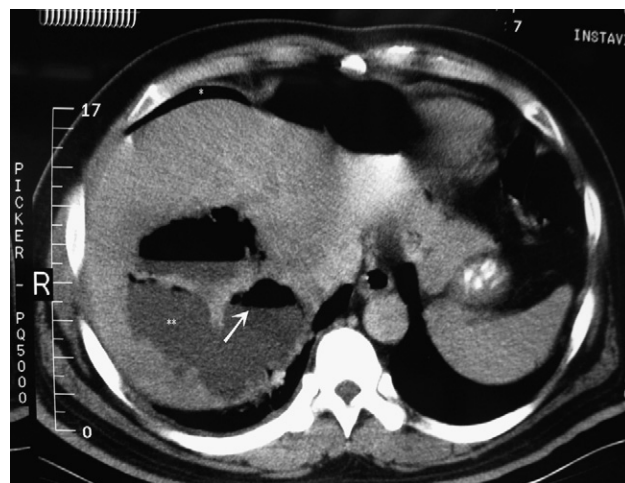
Computed tomography showing a gas-containing liver abscess () with an air-fluid level (white arrow) in the right lobe of the liver and pneumoperitoneum (*).
